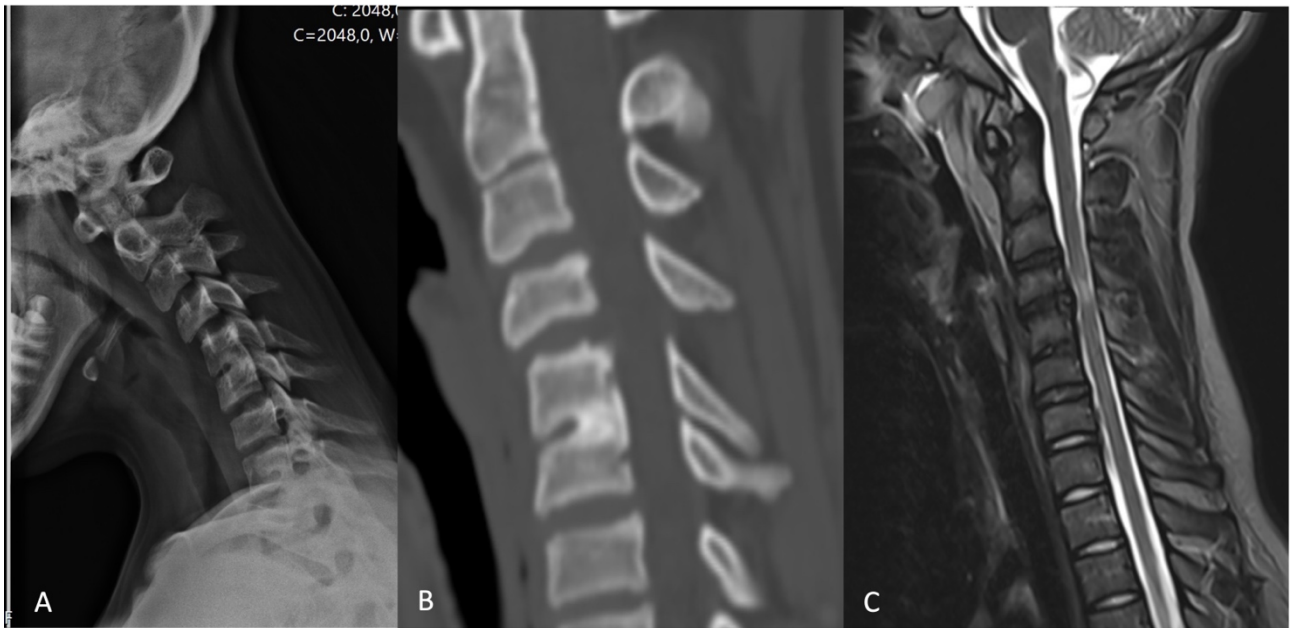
Preoperative imaging. A) preoperative Flexion Cervical X-Ray showing C5-C6 posterior vertebral body fusion and C4 anterior listhesis. B) Preoperative sagittal CT-scan that confirm C5-C6 posterior vertebral body fusion and the reduction of C4 listhesis in neutral position.
